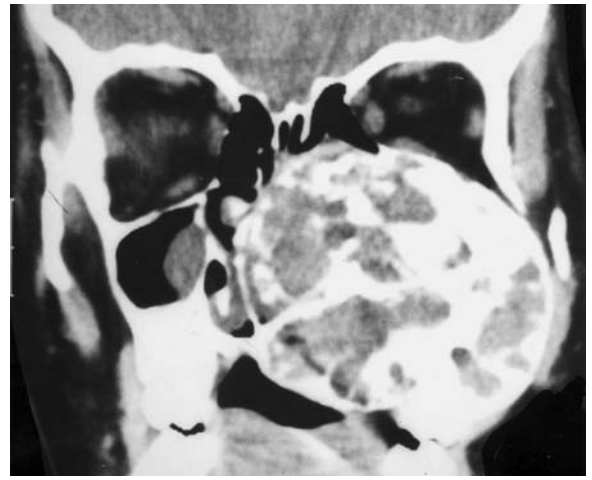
A 10-year-old girl with slowly progressing enlargement of the left maxillary region and secondary ptosis of the left eye. Diagnosis: ossifying fibroma of the left maxillary bone. a Portrait of the patient. Note narrowing of the palpebral fissure with secondary ptosis of the left eye due to a maxillary mass. b Coronal CT, demonstrating a sharply defined, sclerosing mass with osseous trabeculae, occupying and enlarging the entire left upper jawbone. Note the diminution of the left orbit with elevation of the orbital floor, dislocation of the nasal septum to the right, and that no left maxillary sinus nor distinct maxillary structures are seen. (With permission of ROHRBACH and LIEB 1998)
